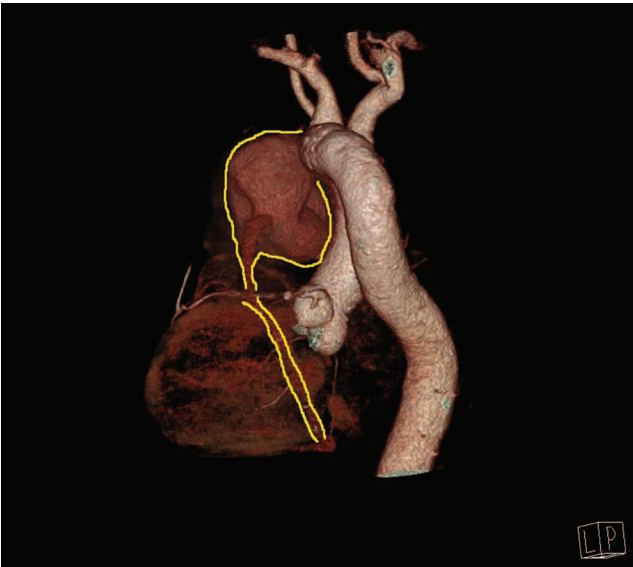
b. Computed tomography of the thoracic aorta with contrast. Contour of the external size of the aneurysmally dilated lumen of the arteriovenous shunt
